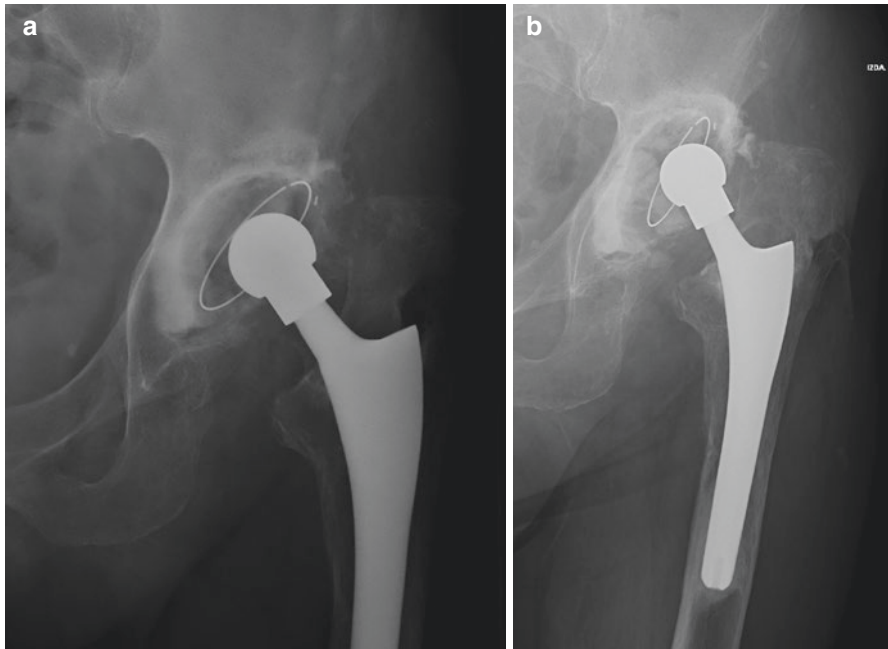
(a) Postoperative radiograph after impacting allograft bone grafting with a cemented cup used in revision surgery. (b) Postoperative radiographs at 10 years after operation. A cup tilt is observed but the clinical outcome is very good
